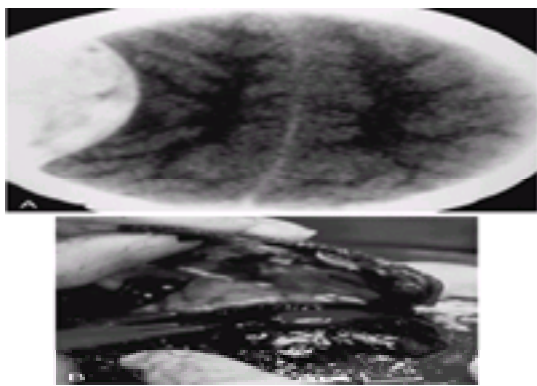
Epidural hematoma. This 8-year-old boy presented after a sledding accident. He had no loss of consciousness, but he complained of headache and vomiting. A head computed tomography (CT) scan (A) shows the classic biconvex hyperdensity of an epidural hematoma. He proceeded to the operating room, where a large mass of clotted blood (B) was removed.
